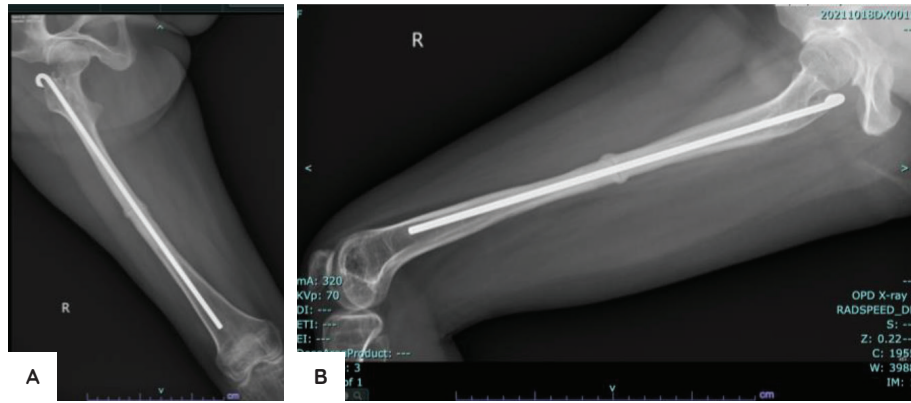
Right femur x-rays (with fixation). Anteroposterior x-ray of the right femur showing healed pathologic fracture and adequately inserted implant (A). Lateral x-ray of the right femur showing healed pathologic fracture and adequately inserted implant (B).
